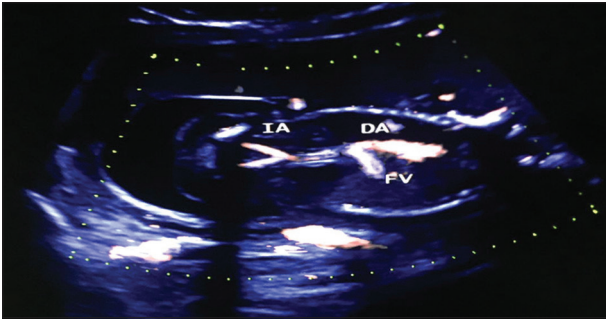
Feeding vessel from the aorta to the lung lesion in Doppler ultrasound in coronal view. (DA: Descending Aorta, FV: Feeding Vessel, IA: Iliac Arteries)
